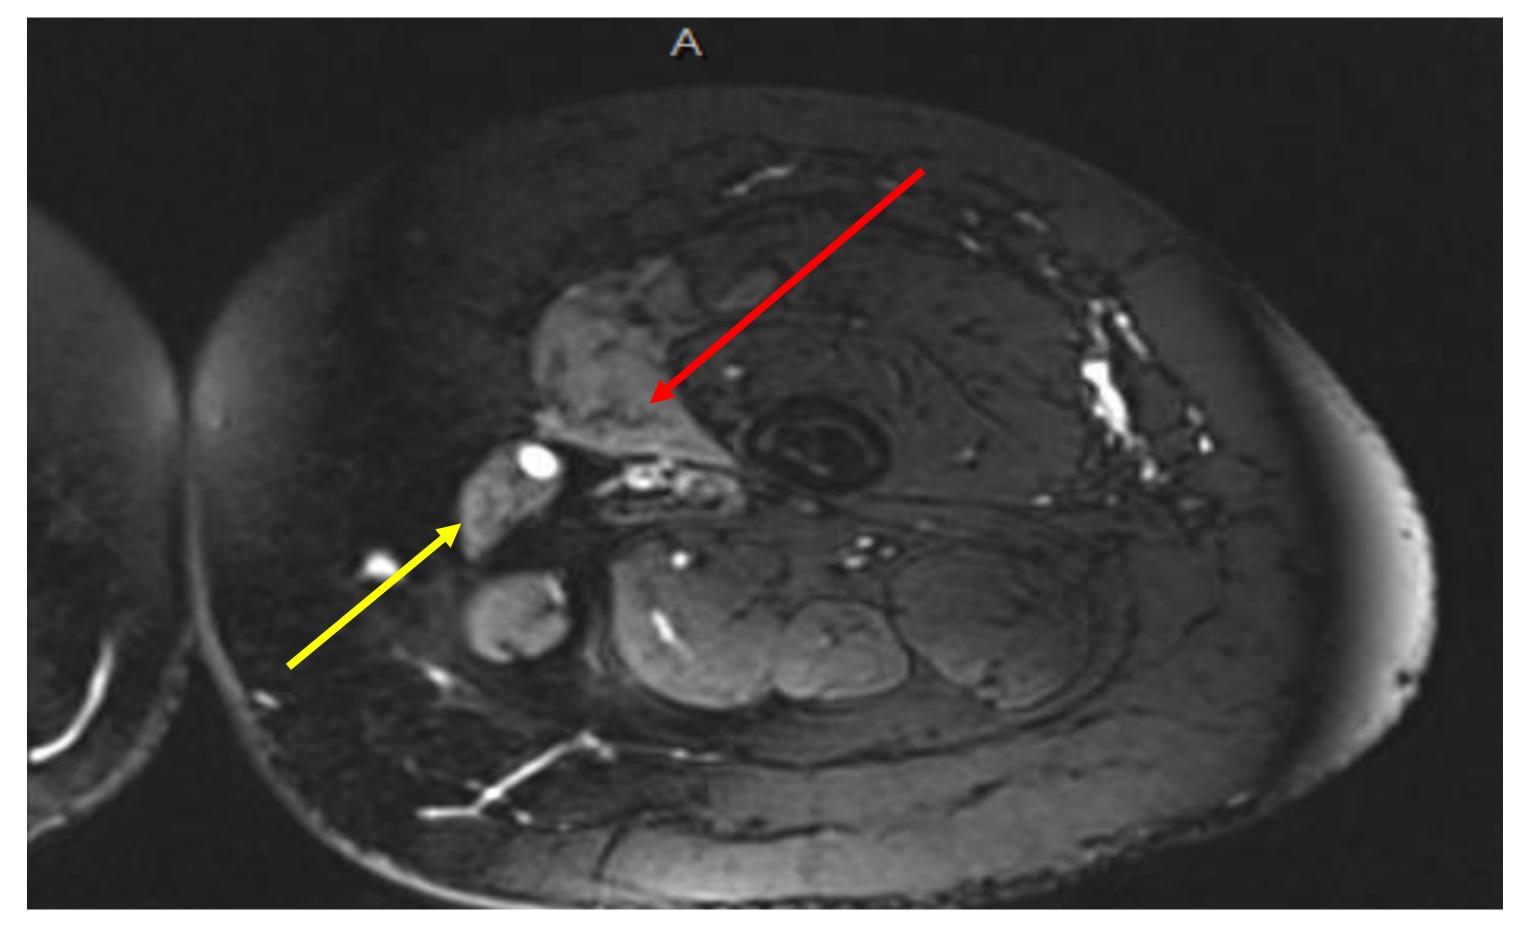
T2-Weighted MRI Thigh, red arrow pointing to edematous vastus medialis and yellow arrow pointing to edematous sartorius, secondary to femoral nerve entrapment and denervation
